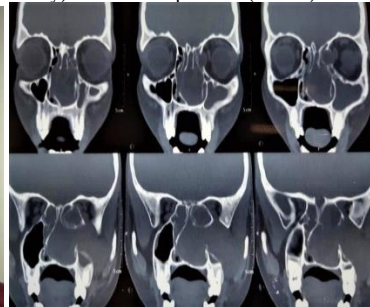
Mass seen on CT scan of side of face
